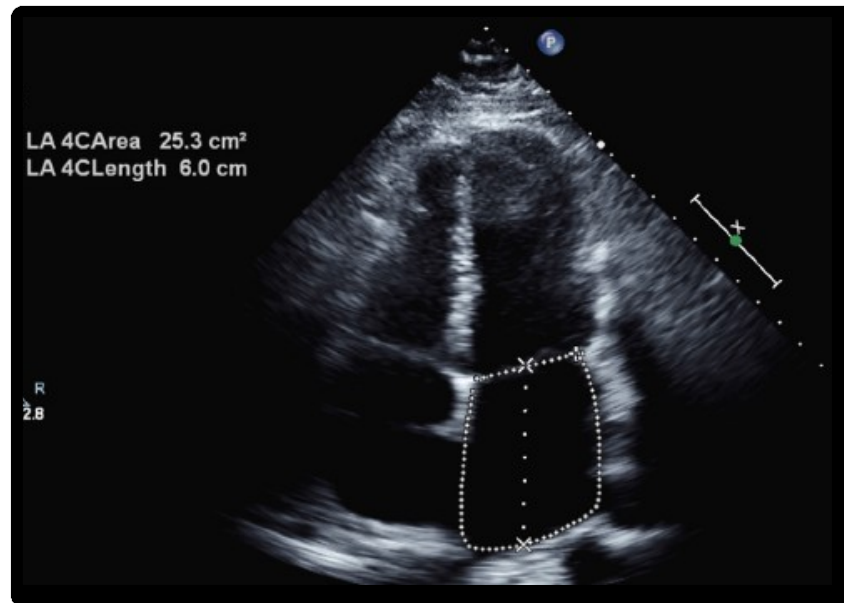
Echocardiography four chamber view showing bi-atrial enlargement in restrictive cardiomyopathy
